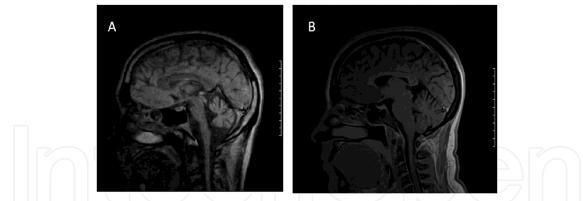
MRI scans of a SCA2 patient (age 40 years; disease duration 8 years, CAG repeat size 39 units, SARA score 19) (A) and a healthy control (age 40 years, SARA score 0) (B). Note the severe atrophy of cerebellum and brainstem in the SCA2 subject.
